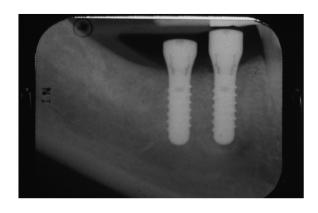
Four months postsurgery. Radiograph shows improved bone radiodensity around implants #29 and #30.
